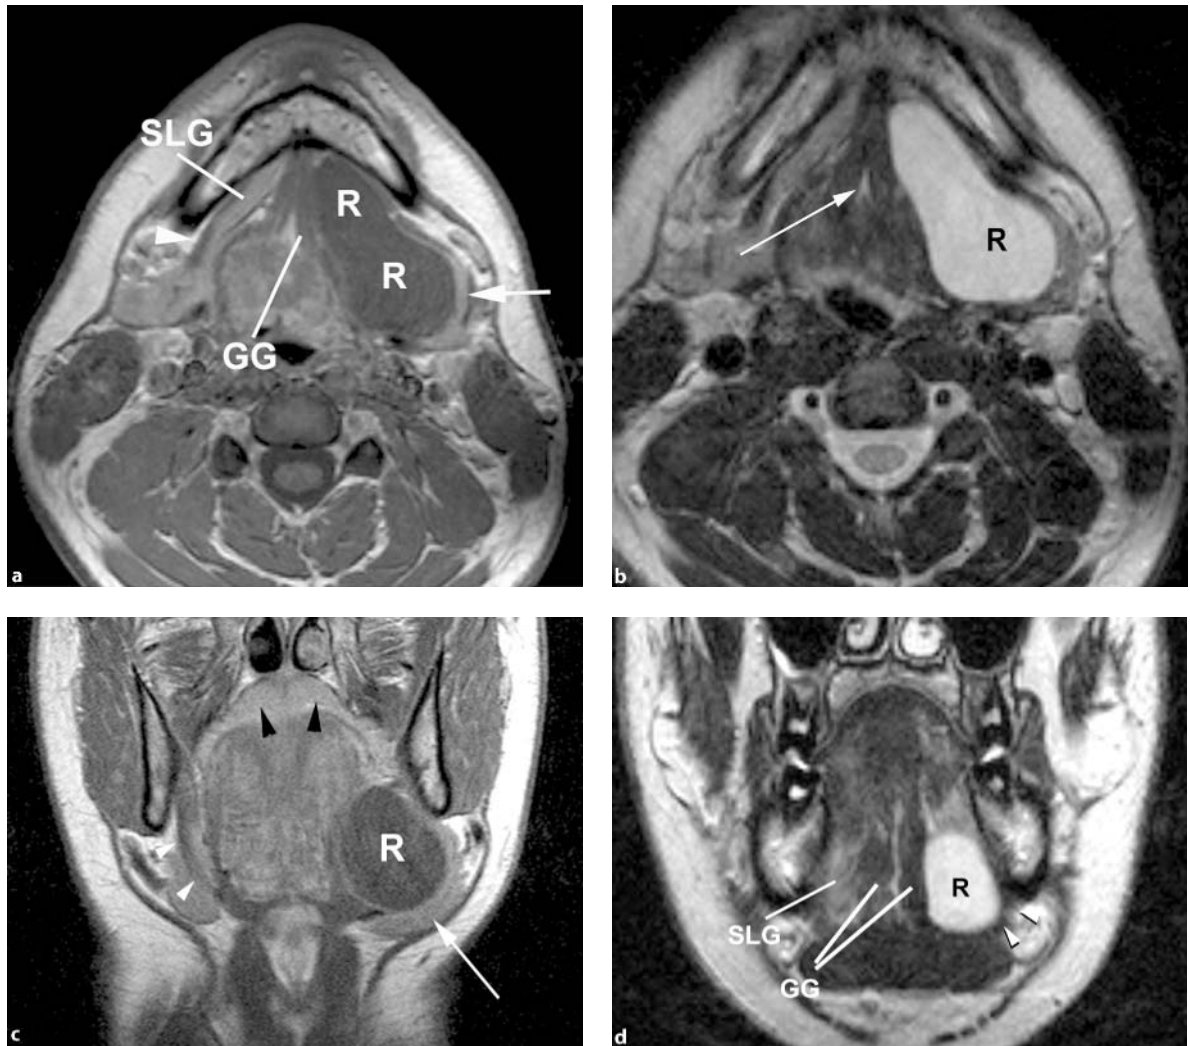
Ranula, MRI. a Axial T1-weighted image after contrast. The ranula (*R*) fills the sublingual space and protrudes beyond the mylohyoid muscle into the submandibular space indenting the submandibular gland (*arrow*). Genioglossus muscle (*GG*), normal sublingual gland on the opposite side (*SLG*), mylohyoid on the normal side (*arrowhead*). b T2-weighted images axial plane. The ranula (*R*) is clearly defined by the high signal. Midline fatty raphe of the tongue (*arrow*). c Coronal T1-weighted image after contrast. The ranula (*R*) fills the sublingual space and displaces the submandibular gland (*arrow*). Normal mylohyoid on the opposite side (*white arrowheads*), minor salivary glands along the roof of the mouth (*black arrowheads*). d Coronal T2-weighted image. The ranula (*R*) shows high signal and is found between the genioglossus muscle (*GG*) and the mylohyoid muscle (*arrowheads*) in the sublingual space. Normal sublingual gland (*SLG*) on the opposite side
